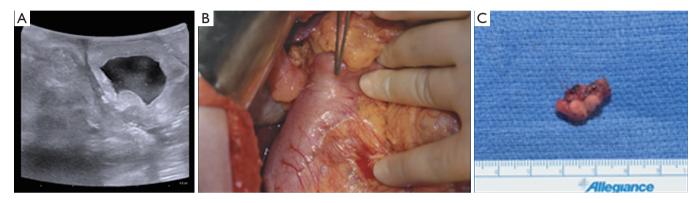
Resection of gastrinoma from duodenal wall. (A) Surgeon-performed intraoperative ultrasonography of duodenal wall demonstrating a small, circumscribed hypoechoic mass in submucosa representing a gastrinoma; (B) Appearance of serosal surface of duodenum with small intramural tumor mass; (C) Resected gastrinoma bivalved to demonstrate gastrinoma.
